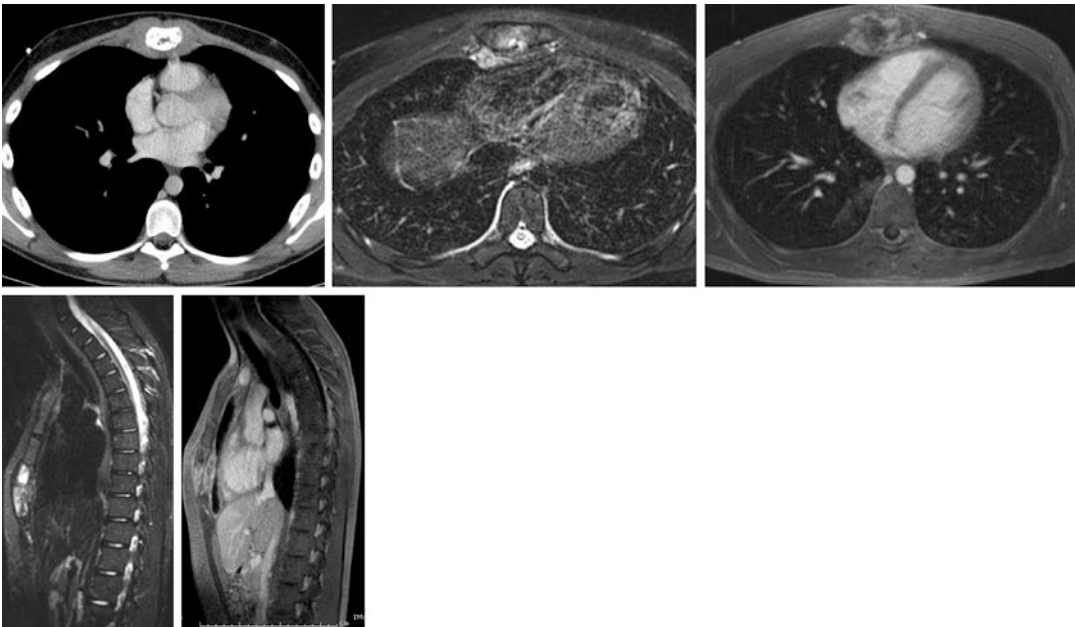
A soft tissue mass surrounding and infiltrating the corpus sterni was detected at CT of a 21-year-old male and verified at T2 and T1 after contrast enhancement. Transversal and sagittal plane were acquired in prone
